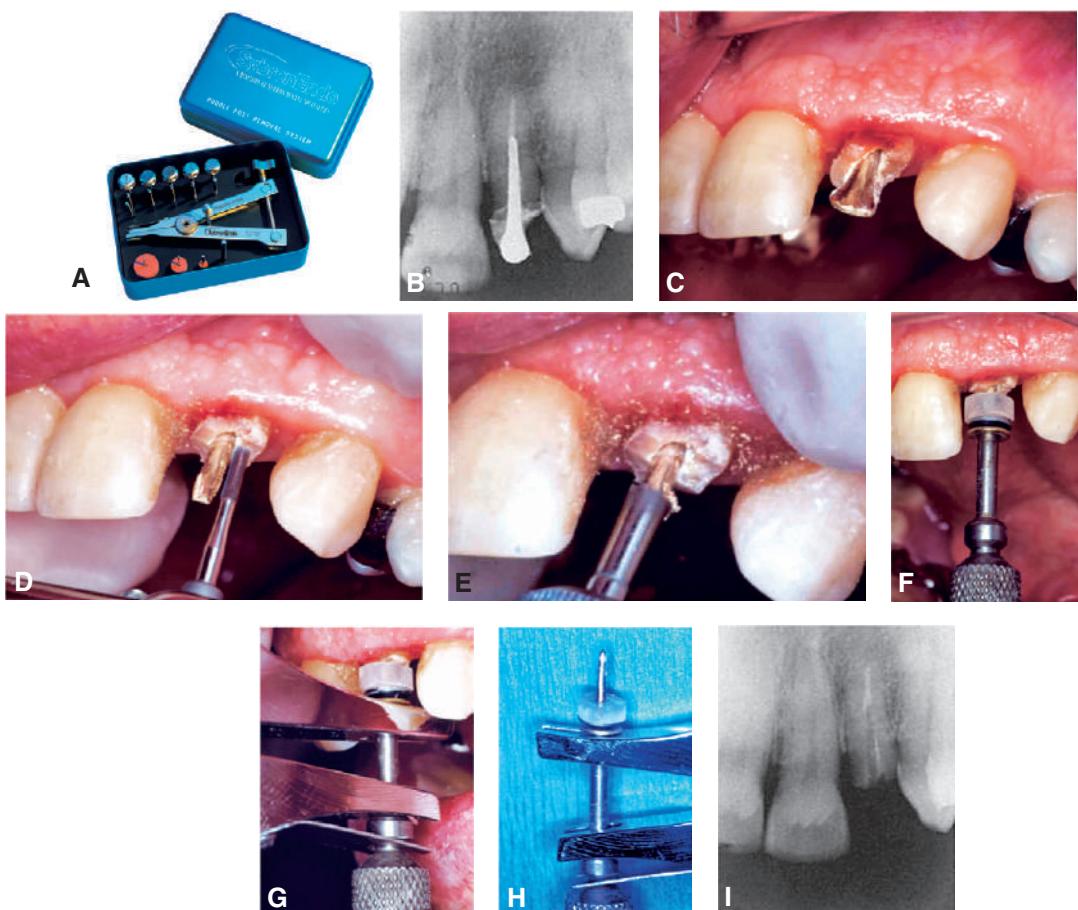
Post removal by extractor. (A) Ruddle Post Removal System. It includes pliers, trephine burs, mandrels, and washers. (B) Preoperative radiograph of the left maxillary lateral incisor with a post. (C) Note the flared shape of the post in this preoperative view and the height of the surrounding tooth structure. (D) A high-speed bur is used to free the post from coronal tooth structure and parallel its sides. (Note: An ultrasonic device may be used at this point to disturb the cement interface.) (E) A trephine bur machines the post to the correct diameter and places threads for the mandrel. (F) The mandrel is threaded onto the post with special washers, which distribute the forces from the extractor evenly over the tooth. (G) The beaks of the pliers are fitted onto the mandrel; the knob of the pliers is then rotated, which separates the beaks, and the post is extruded from the tooth. (H) The removed post, still attached to the mandrel and pliers. (I) Radiograph of the lateral incisor after post removal. (A, Courtesy SybronEndo Corporation, Orange, CA. B–H, Courtesy Dr. D.A. Miller.)
